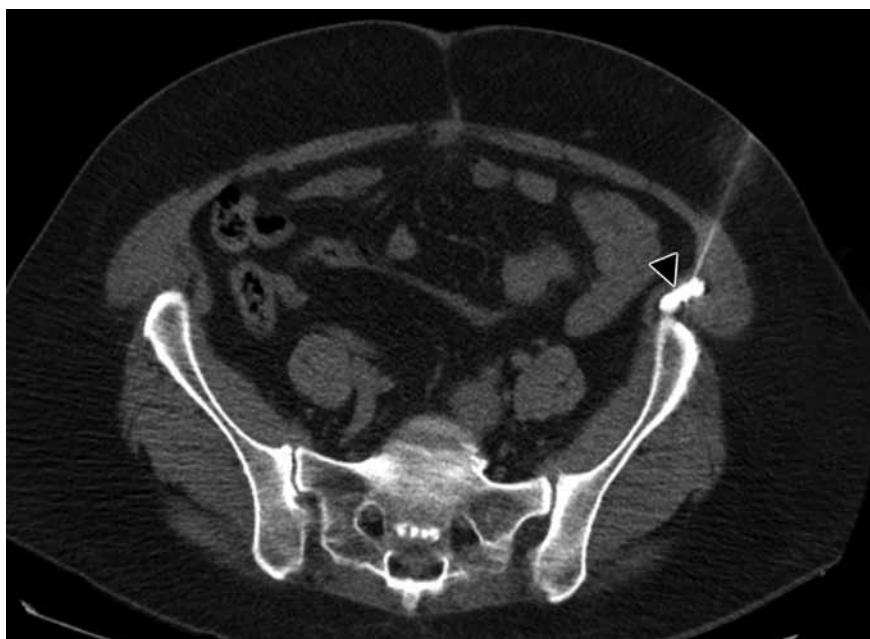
CT slice after injection of contrast media (arrowhead) at defined target.
